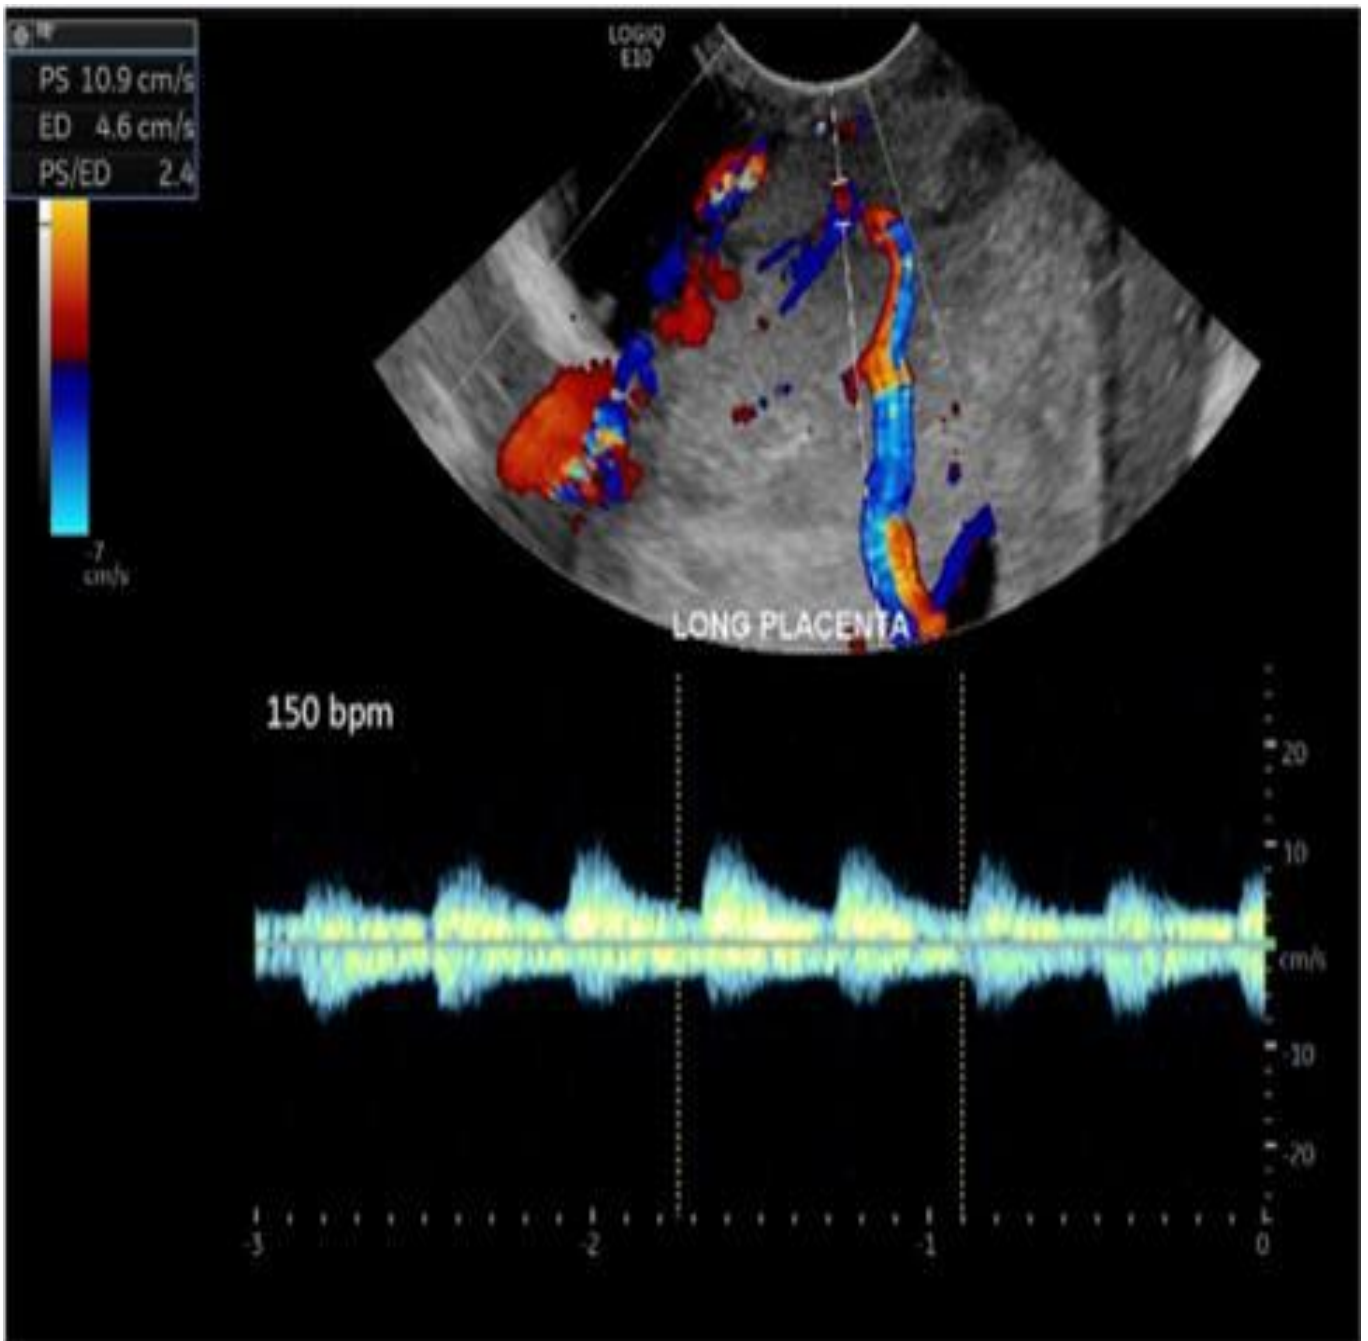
A transplacental fetal artery in a patient with placenta FIGO Grade 2 (increta). Color and spectral Doppler image shows a fetal artery (150 bpm) traversing the width of the placenta nearly to the basal plate. Cited from [33].
